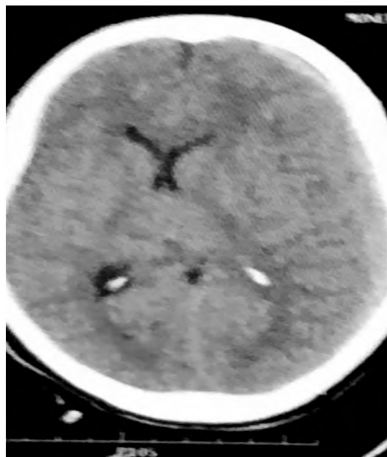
Pre-operative CT brain.
